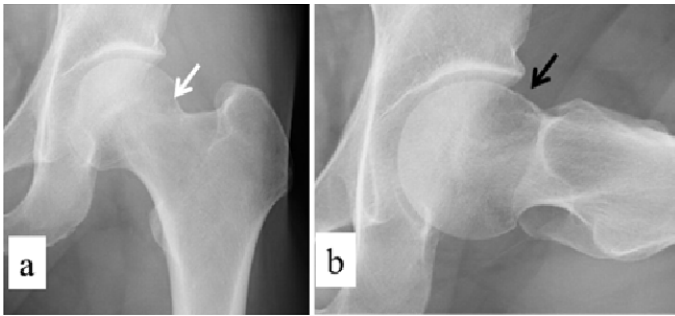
Plain radiographs, (a) AP view. The center-edge angle was 33°. The white arrow indicates a bone cyst, (b) 90° Dunn view. The α angle was 57°. The black arrow indicates a bump at the junction of the femoral head and neck.
